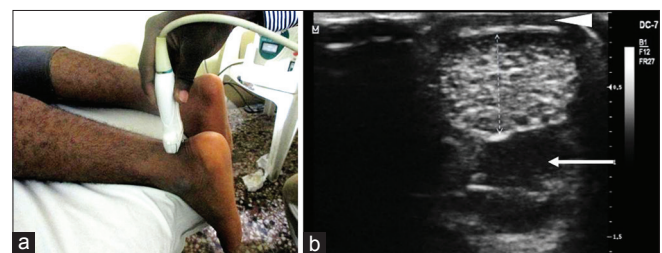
(a) Patient and probe positioning for measuring the Achilles tendon thickness; (b) corresponding sonographic image of the Achilles tendon (short-axis view) showing the skin and subcutaneous tissue (arrowhead), Achilles tendon (between cursors) and pre-Achilles fat pad (arrow)
